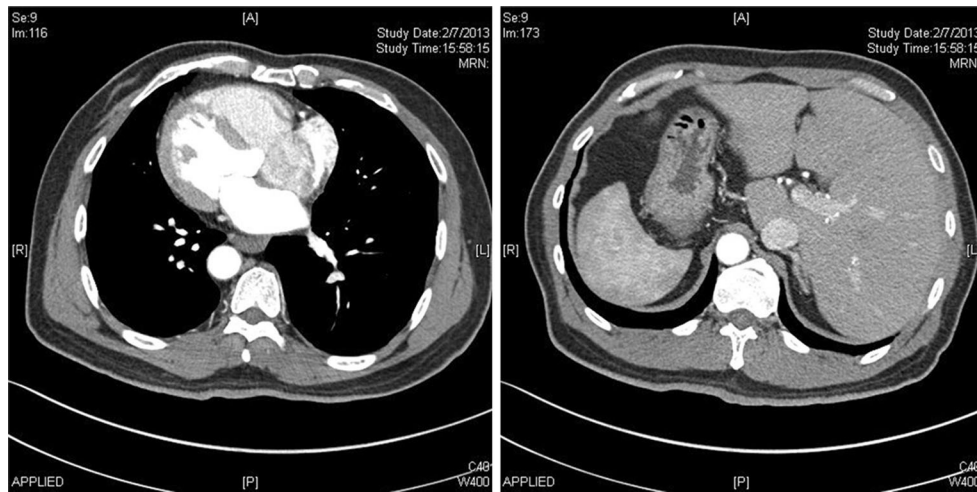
CT scan showing situs inversus
